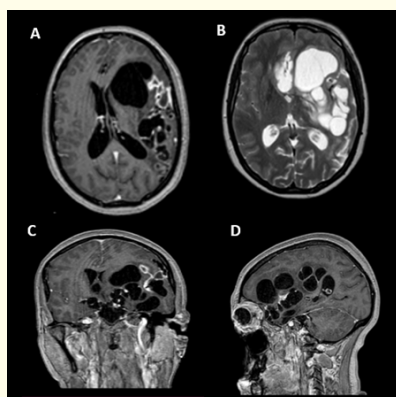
Brain MRI. A: contrast T1, axial view; B: T2, axial view. C: Contrast T1, coronal view; D: Contrast T1, sagittal view.
